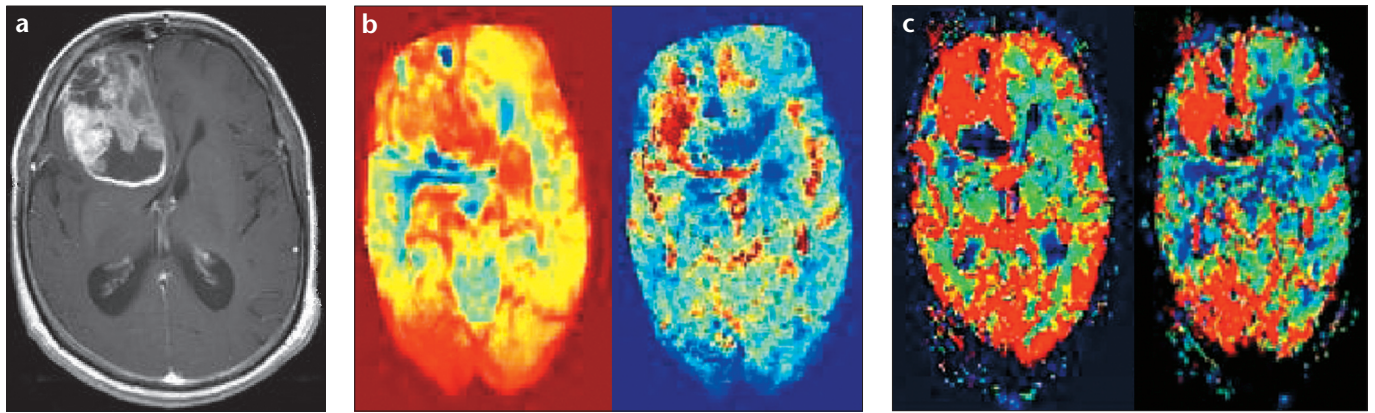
a-c. Patient 14. Transverse post-contrast T1-weighted MR image (a) shows a right frontal glioblastoma multiforme. Corresponding rCBV and rCBF maps of the mass obtained from the homemade software (b) and the commercial one (c). The results are quite comparable, except that there are fewer artifacts in the homemade software.
